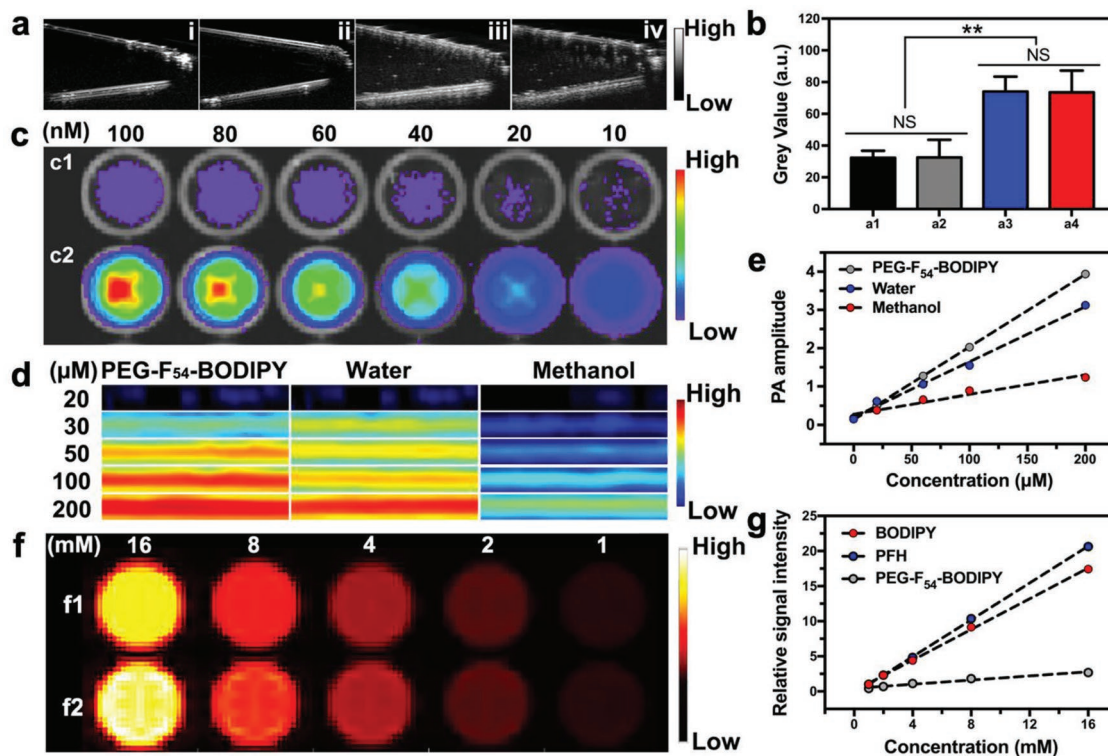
a) In vitro Ultrasonic (US) images and b) the corresponding gray values of water, PEG-F₅₄-BODIPY, PFH@PEG-F₅₄-BODIPY, and oxygenated PFH@PEG-F₅₄-BODIPY, from left to right (20 μM BODIPY, 0.5 v/v% PFH). The values represent the means ± s.d. (*n* = 3; NS, not significant; *P* < 0.01). c) In vitro FL images of PFH@PEG-F₅₄-BODIPY in different solvents (c1: water, c2 methanol). d) In vitro PA images and e) the corresponding PA amplitudes of PFH@PEG-F₅₄-BODIPY in different solvents (d1: water, d2 methanol). f) In vitro MR images and g) the corresponding MR signal intensity of PFH@PEG-F₅₄-BODIPY (f1: BODIPY, f2: PFH).
